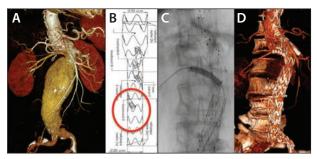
A juxtarenal AAA with kinking of the aorta and upward RRA. Preoperative three-dimensional (3D) CT (A). E-xtra DESIGN ENGINEERING with three antegrade inner branches and one retrograde branch for the RRA (red circle) (B). Intraoperative view of deployment of the bridging stent in the retrograde inner branch (C). The postoperative 3D CT showed no leak and good conformability of the right bridging stent without any kinking (D).
